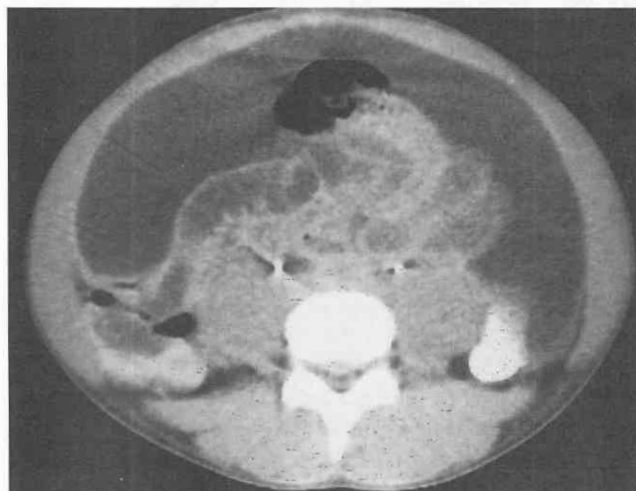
Peritonitis. CT scan through the midabdomen of a patient with peritonitis shows a large amount of peritoneal fluid. The fluid demonstrates a mass effect on the bowel and mesentery.
